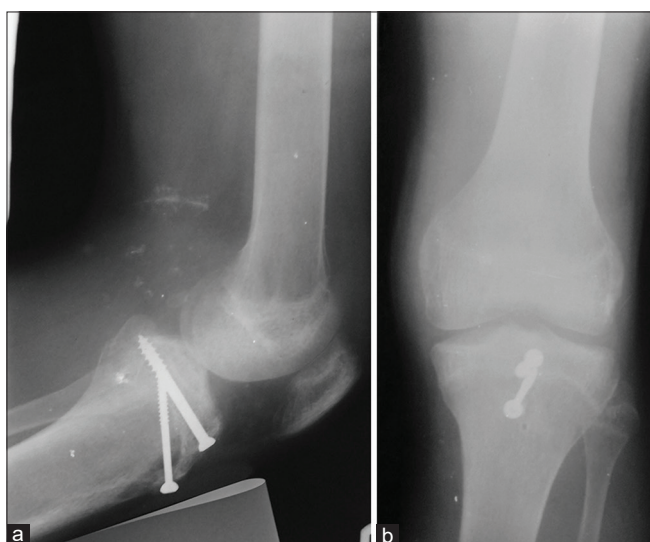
(a and b) Three months post-operative anteroposterior and lateral X-ray films
